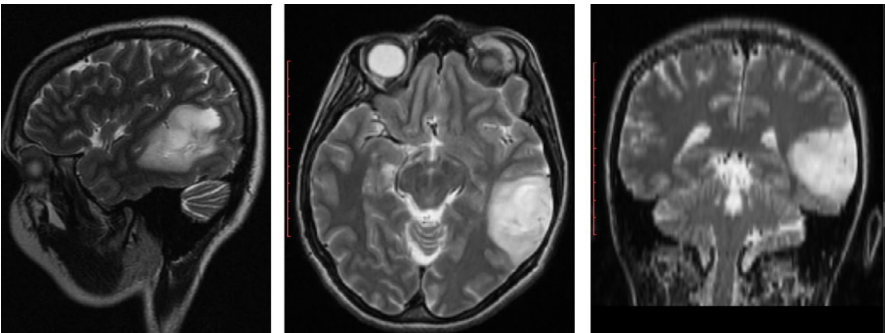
Preoperative MRI with left temporal lobe glioma T2 images
